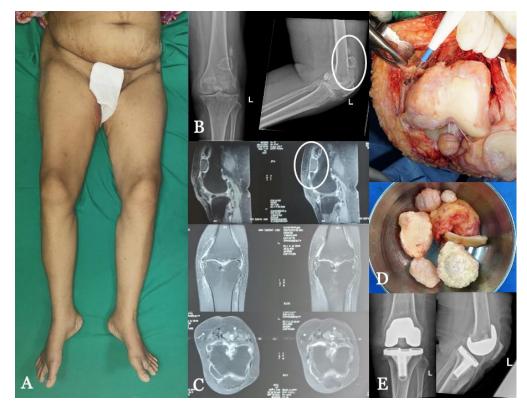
(A) Local condition of both knees preoperatively. (B) Knee X-ray depicting an ossified mass in the infrapatellar region. (C) MRI revealing multiple lesions in the left suprapatellar region with left knee joint effusion, consistent with synovial chondromatosis. (D) Synovectomy performed on the exposed knee joint, and loose bodies were removed. (E) Final construct in the postoperative X-ray.
